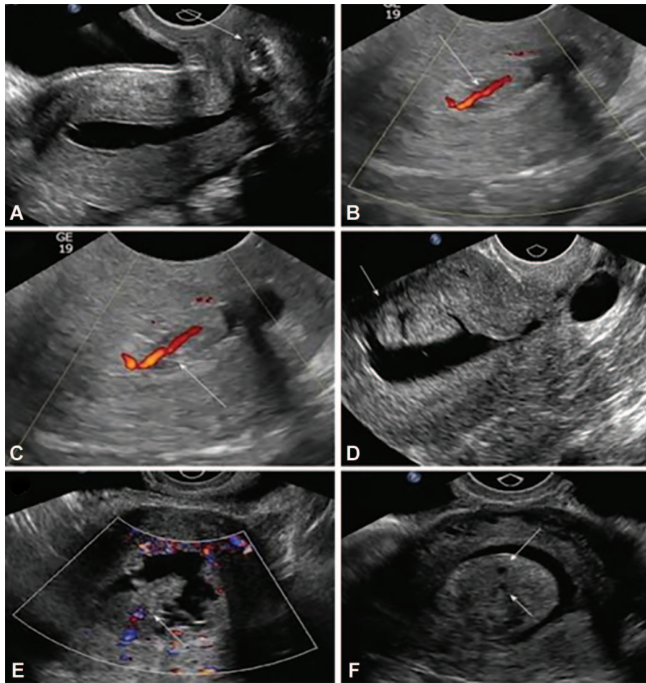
to F: USG and Doppler image of a polyp showing a single feeding vessel
